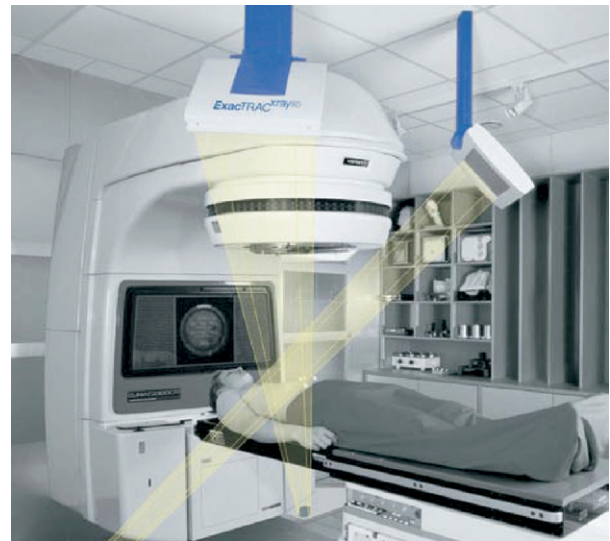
The Novalis body image-guided system showing oblique configurations of the x-ray imaging devices.
